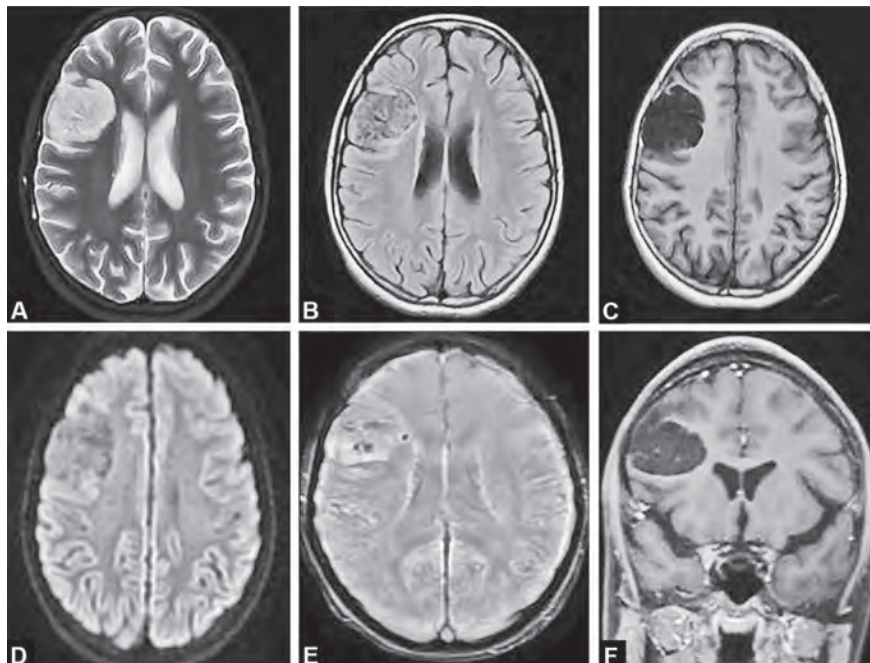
(A) Axial T2W, (B) T2-FLAIR, (C) T1W, (D) DWI, (E) SWI, and (F) coronal post-contrast T1W images show an intra-axial well-circumscribed T2 hyperintense/T1 hypointense lobulated cortical–subcortical lesion is noted in the right frontal lobe, demonstrating partial signal suppression on FLAIR imaging. Susceptibility-weighted imaging (SWI) reveals a few small hypointense foci within the lesion, possibly representing calcifications. There is no evidence of diffusion restriction or post-contrast enhancement. Additionally, no surrounding edema or significant mass effect was observed
